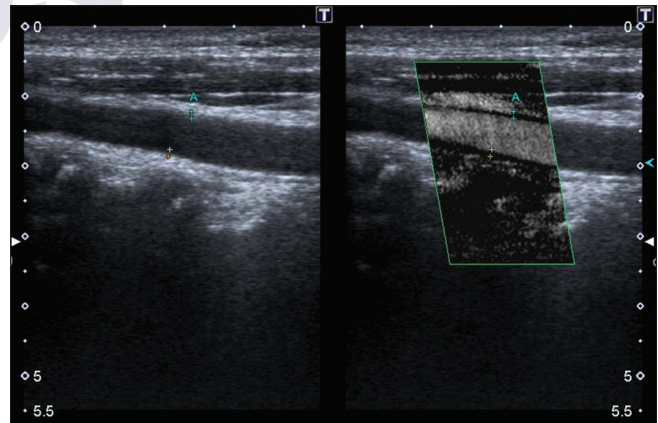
A 35 year old female who presented for regular checkup. High-resolution Ultrasonography showing twin-view of left Common Carotid Artery by B-mode (on the the left) and SMI (on the right).
